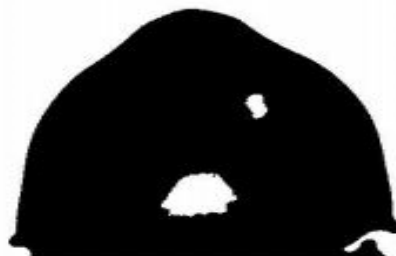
Dental CT Image after segmentation using threshold method.
